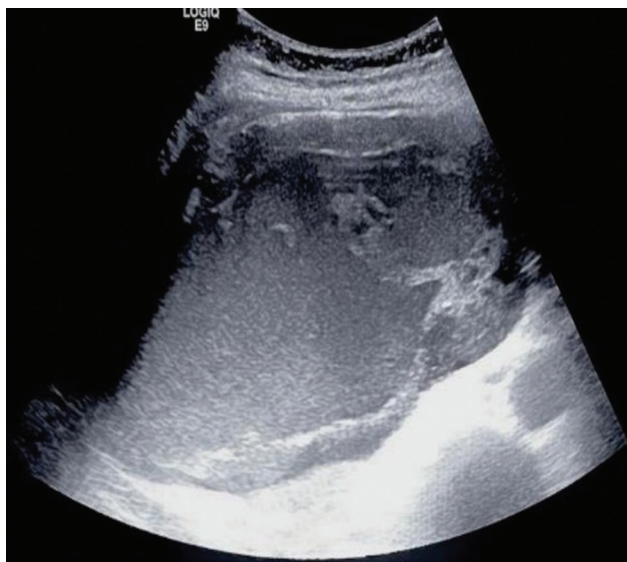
Ultrasound image of a retroperitoneal complex cyst.
